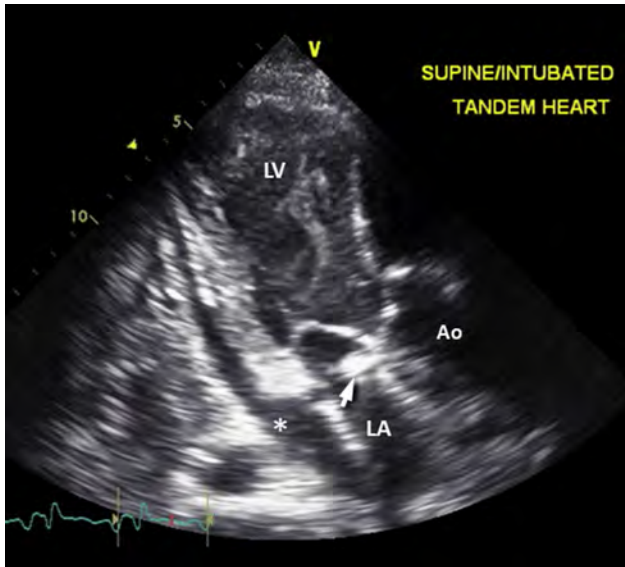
Severe left ventricle (LV) spontaneous echocardiography contrast in a patient with complete LV “bypass” (no aortic valve opening) during TandemHeart support. The risk of LV thrombus is high without systemic anticoagulation therapy. Left Atrium (LA), Aortic Root (Ao), pericardial effusion (*), Tandem Heart inflow cannula (arrow). See also [Video 54](#).
